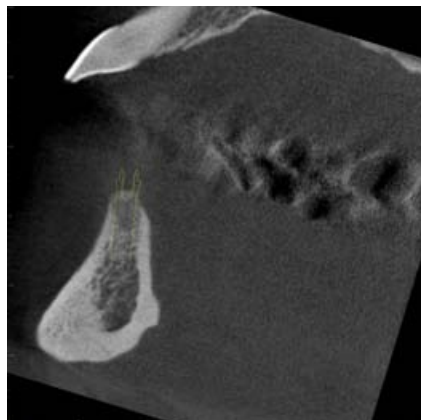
Sagittal CBCT image for implants in the position of the right and left lateral incisor
